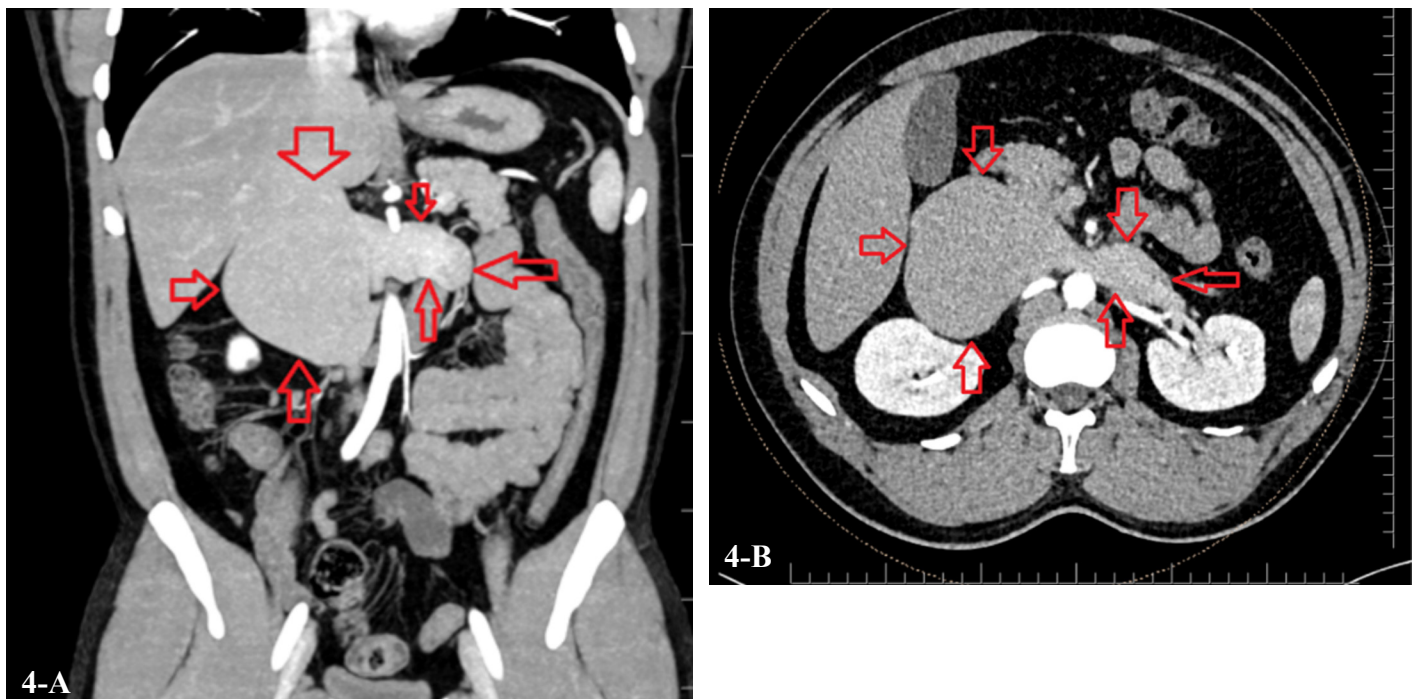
A-B. January 2018 CTA
